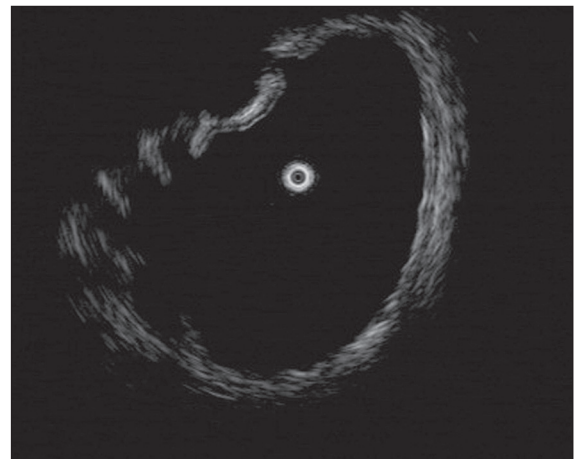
The deeper section cannot be visualized using a miniature probe ultrasound, due to the calcifications
